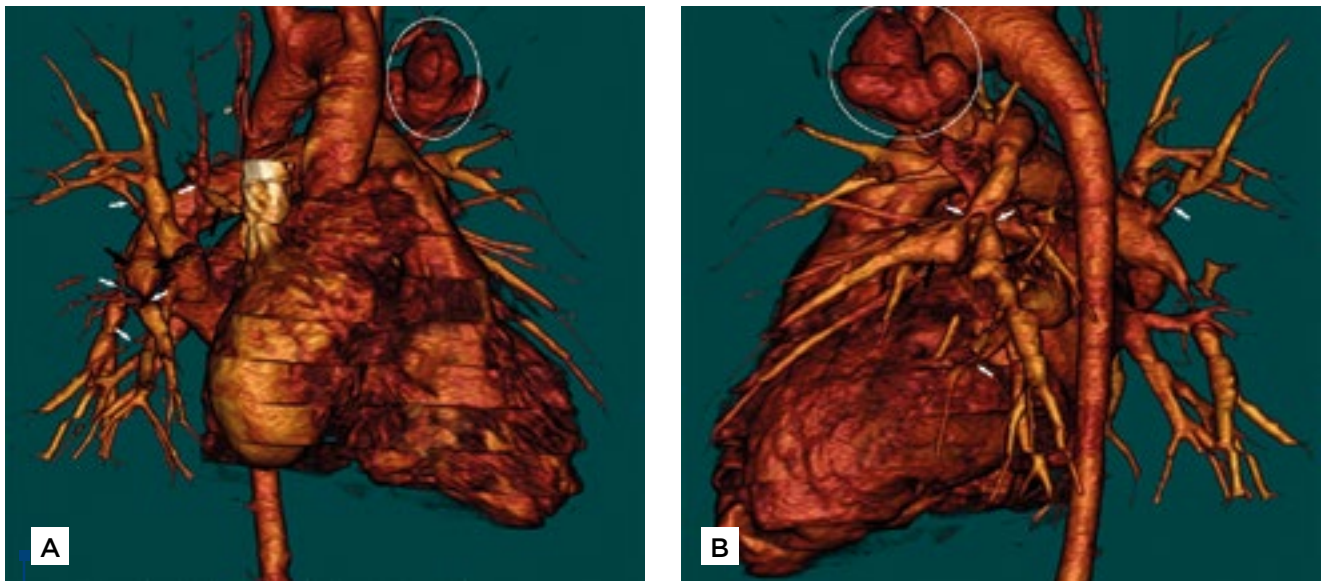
CT-angiography of the chest (cardiovascular reconstruction) showing left apical poststenotic aneurysm (circles), multiple pulmonary arteries stenoses with poststenotic dilatation (some pointed with arrows)
